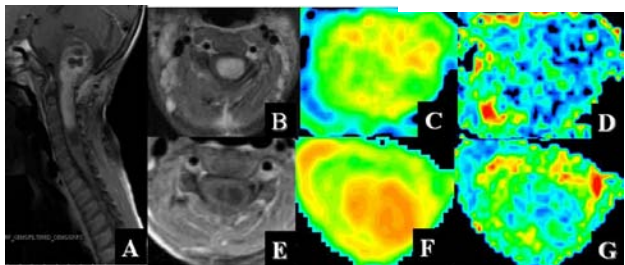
A patient with astrocytoma. A: Sagittal T1-weighted post-contrast image; B and E: Axial T1-weighted post-contrast image; C and F: ADC image; D and G: FA image. B, C and D are images at C2-3 level; E, F and G are images at the C5 level.
